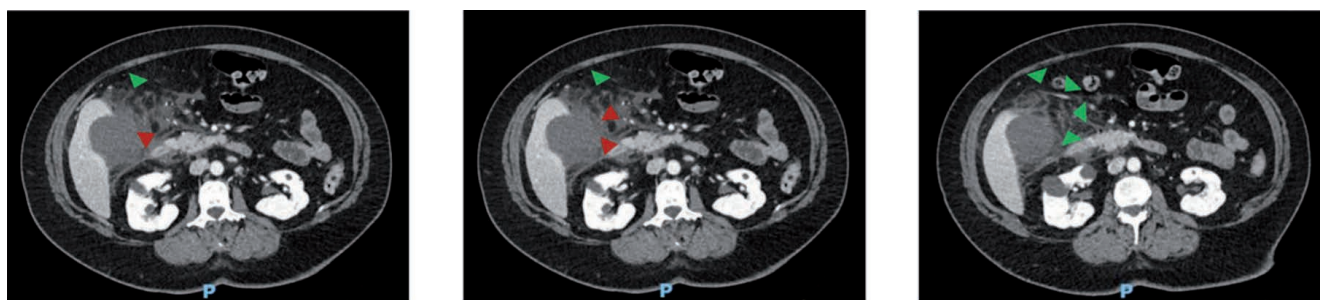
CT scan images performed upon emergency room admission. In red arrowheads, the irregularities in the gallbladder wall, and in green, the pericholecystic effusion.
